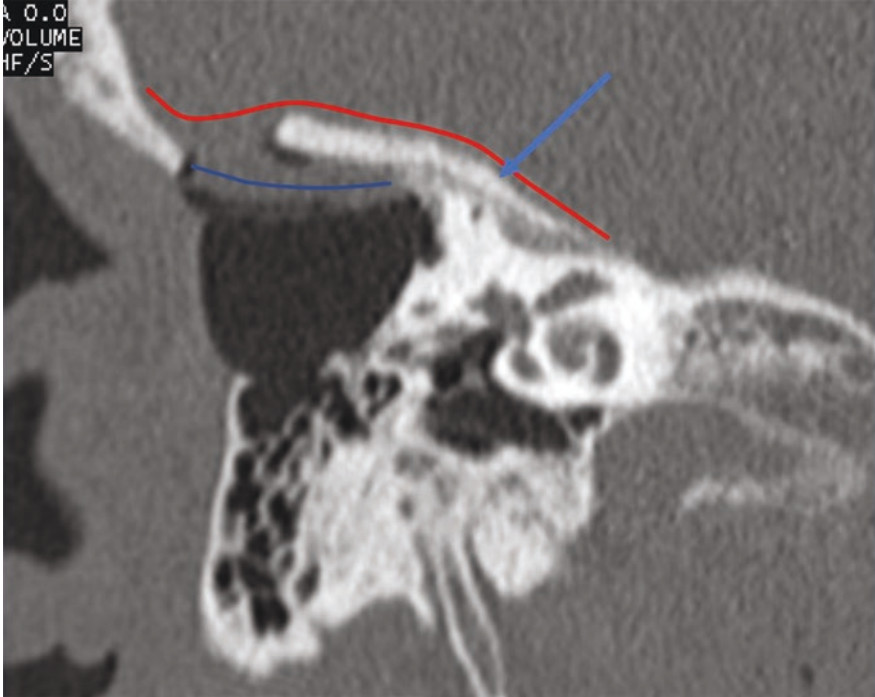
Postoperative CT scan after resurfacing with silastic sheeting (red) and calvarial bone (arrow). The blue line denotes bone wax
